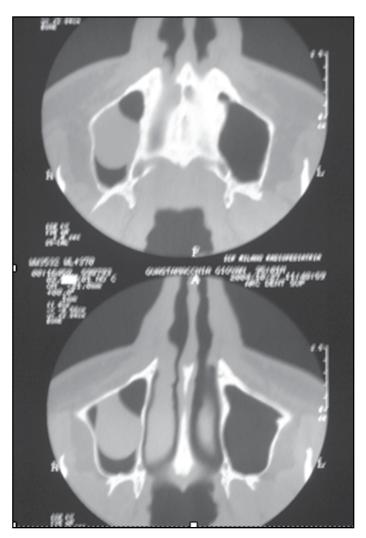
CT scan exam shows the presence of a neoformation in the right maxillary sinus.
